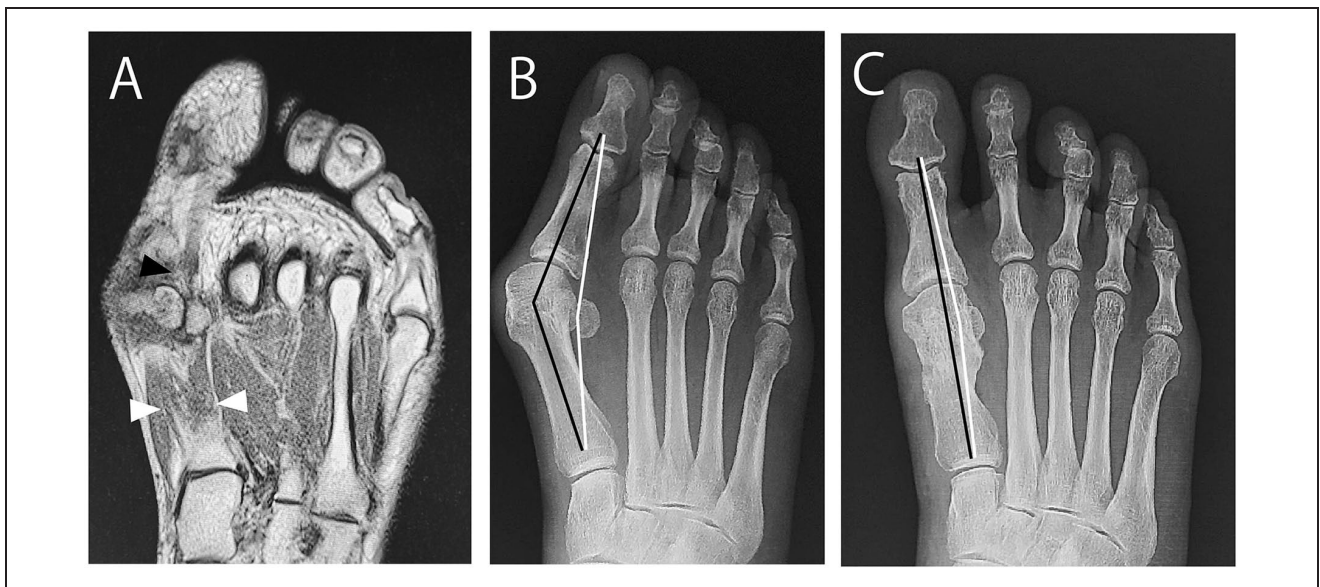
The difference between the bone alignment and the tendon alignment. (A) Preoperative magnetic resonance imaging. The flexor hallucis longus tendon (black arrowhead) passes between the sesamoids. The flexor hallucis brevis (white arrowheads) tendons run along the flexor hallucis longus and reach the base of the first metatarsal. (B) Preoperative radiograph. In severe hallux valgus, the flexor tendon alignment (white line) is shorter than the bone alignment (black line), thus concealing the flexor tendon shortening. (C) Postoperative radiograph. After correcting the hallux valgus, the bone alignment is almost as long as the flexor tendon alignment. This reveals the tendon shortening, which clinically manifests as the postoperative ROM limitation.
